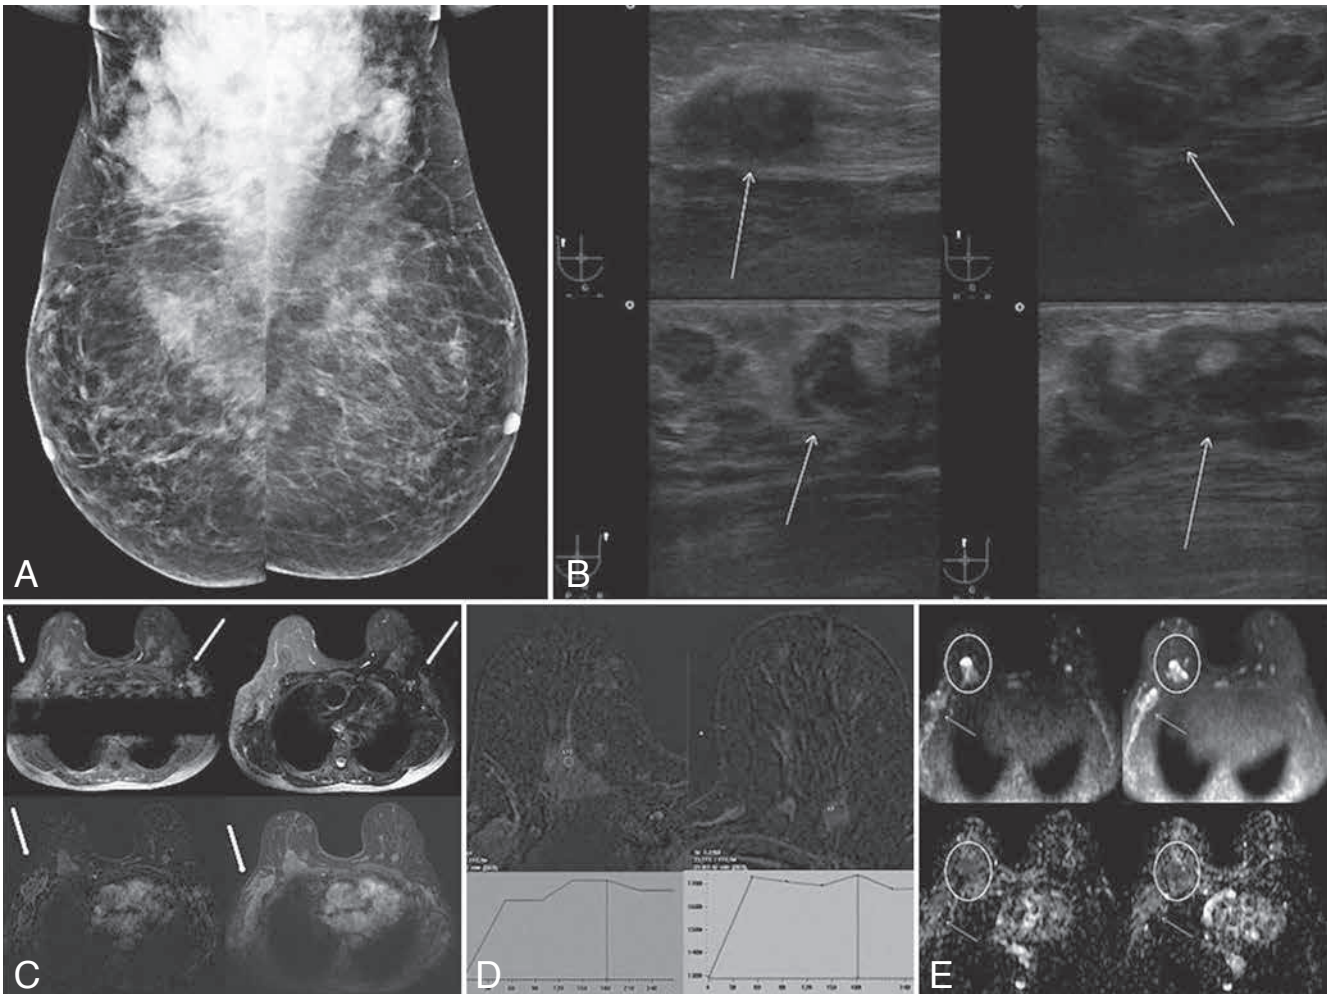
A. On mammographic examination of right and left breasts, there are irregular lesions extending from both upper outer quadrant to axillar sites. B. On ultrasonographic examination, the images at the upper are breast lesions, and the lesions at the lower part are axillar lesions. The breast lesions are hypoechoic, solid lesions with irregular contours. There are hyperechogen areas at the center of the lesions which were thought as hilum (arrows). C. On MR views, the images at the upper part are, axial fat saturated T2 weighted and the images at the lower part are axial post-enhanced subtracted images. There are irregular, enhanced lesions at the anterior of bilateral pectoral muscles extending to both axillar parts (arrows). D. There are type 2 pharmacokinetic curves obtained from the breast lesions. E. At the upper part there are b-1000 diffusion weighted images and at the lower part apparent diffusion coefficient images. There are marked diffusion restriction at the lesions (Circles and arrows).
